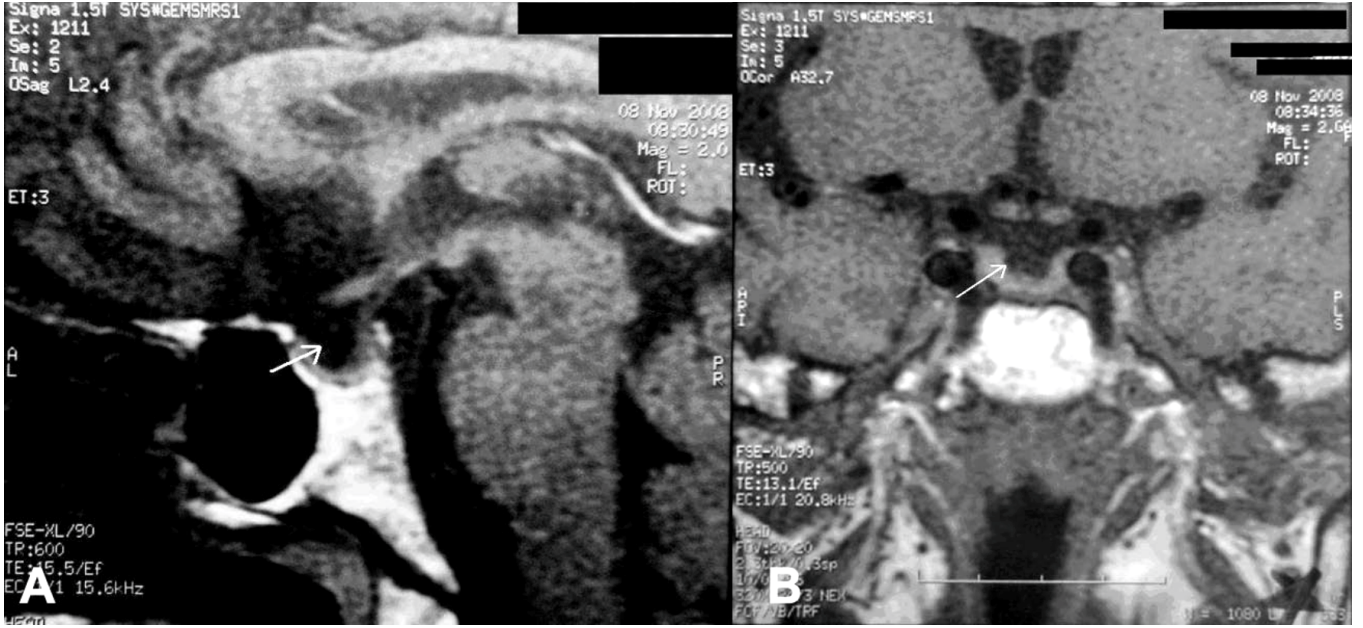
Coronal (A) and Axial (B) MRI pictures of the patient with partial empty sella.
